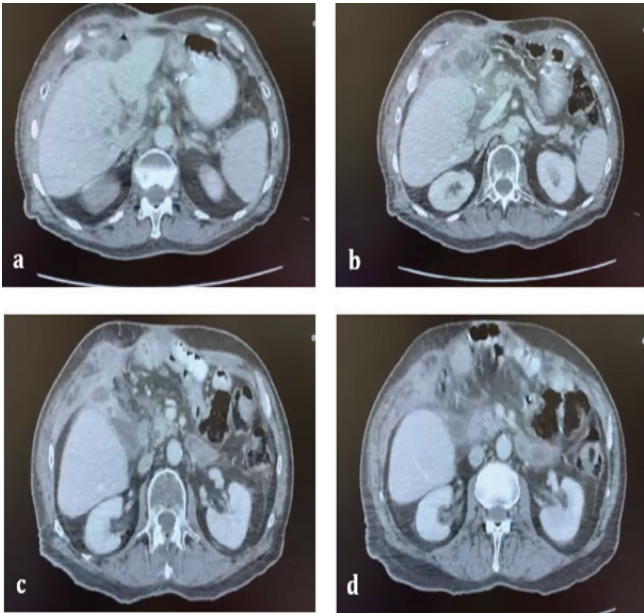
Abdominal CT imaging sections obtained after the patient’s presentation, showing images of an abscess and enterocutaneous fistula
